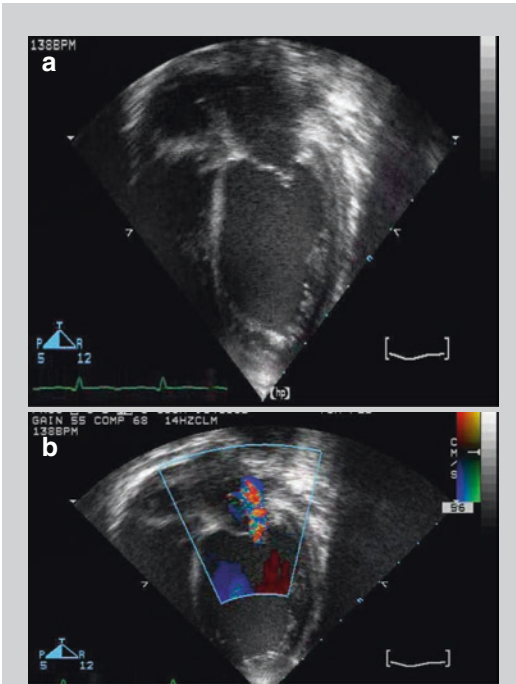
(a) Fulminant myocarditis – echocardiographic image, apical four-chamber view. (b) Fulminant myocarditis with mitral regurgitation
